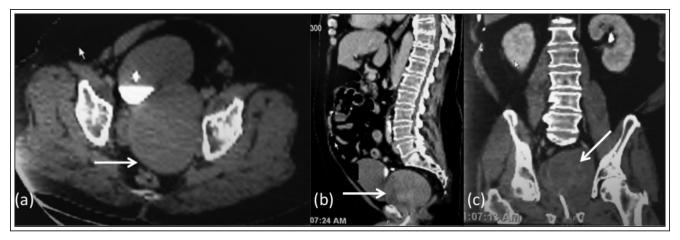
CT images of the abdomen and pelvis. Arrows indicate the location of the leiomyoma. In images a and b the bladder is seen partially filled with contrast and displaced anteriorly.
